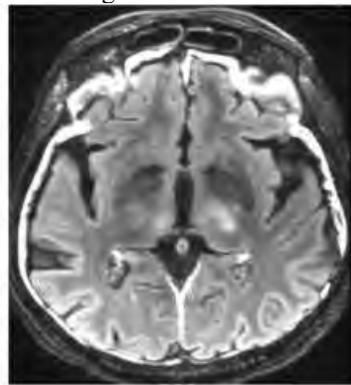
Axial post-contrast T2 FLAIR image demonstrates abnormal T2 hyperintense signal in the bilateral thalami extending into the posterior limbs of the internal capsule. Bilateral subdural fluid collections are also noted in this patient with viral encephalitis and seizures.
